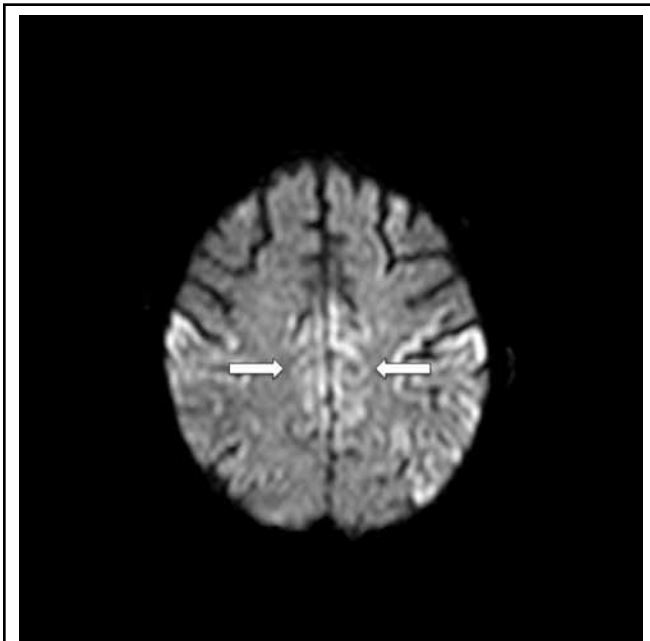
MRI diffusion-weighted images showing hyperintense signal in the cingulate gyrus.
